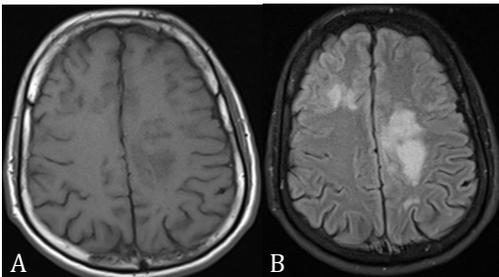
(A & B): MRI brain axial sections demonstrate T1 hypointense & T2 hyperintense lesions in bilateral corona radiata.
